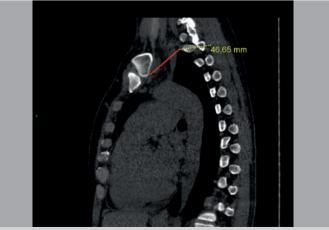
Computed tomography image in sagittal section showing sternoclavicular joint to the pulmonary apex.
